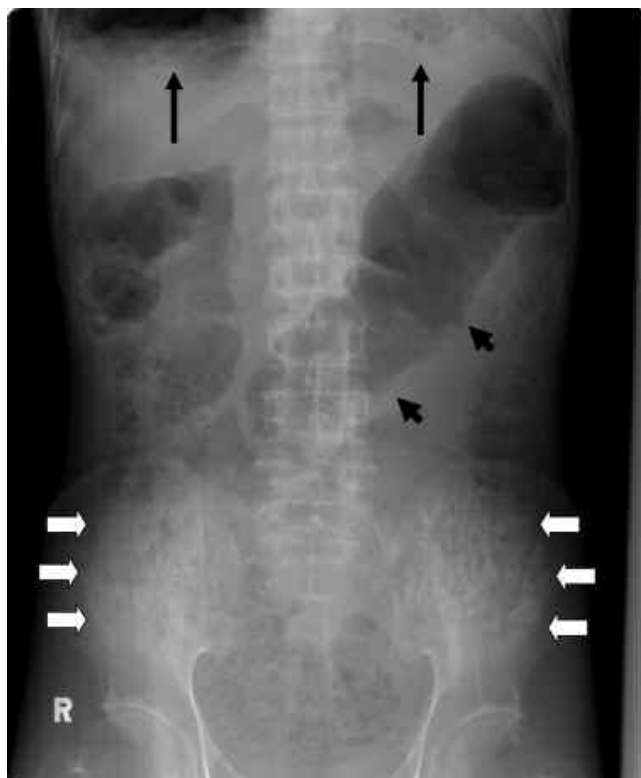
The abdominal radiograph shows evidence of dilatation of the transverse colon, with normal mucosal features (arrowheads) and fecal loading.
